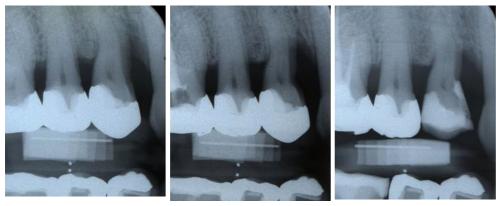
Of each patient standardized radiographs were obtained pre-surgical, 12 and 120 month after surgery (patient #1)
